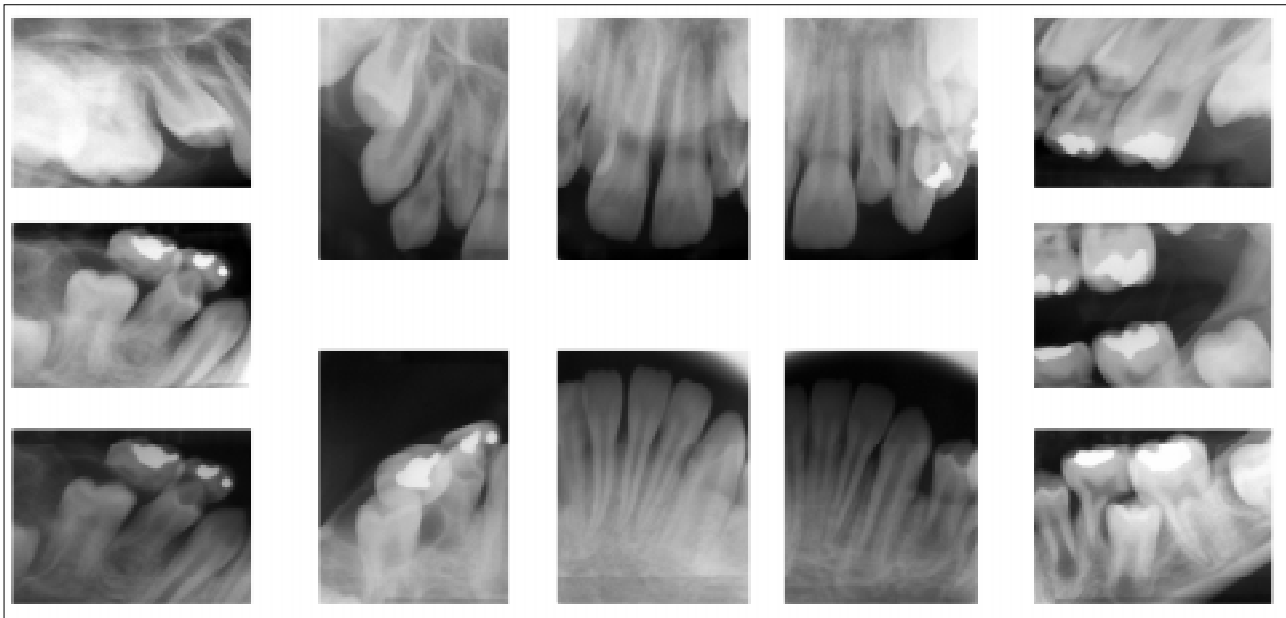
Full mouth radiographs one year later
